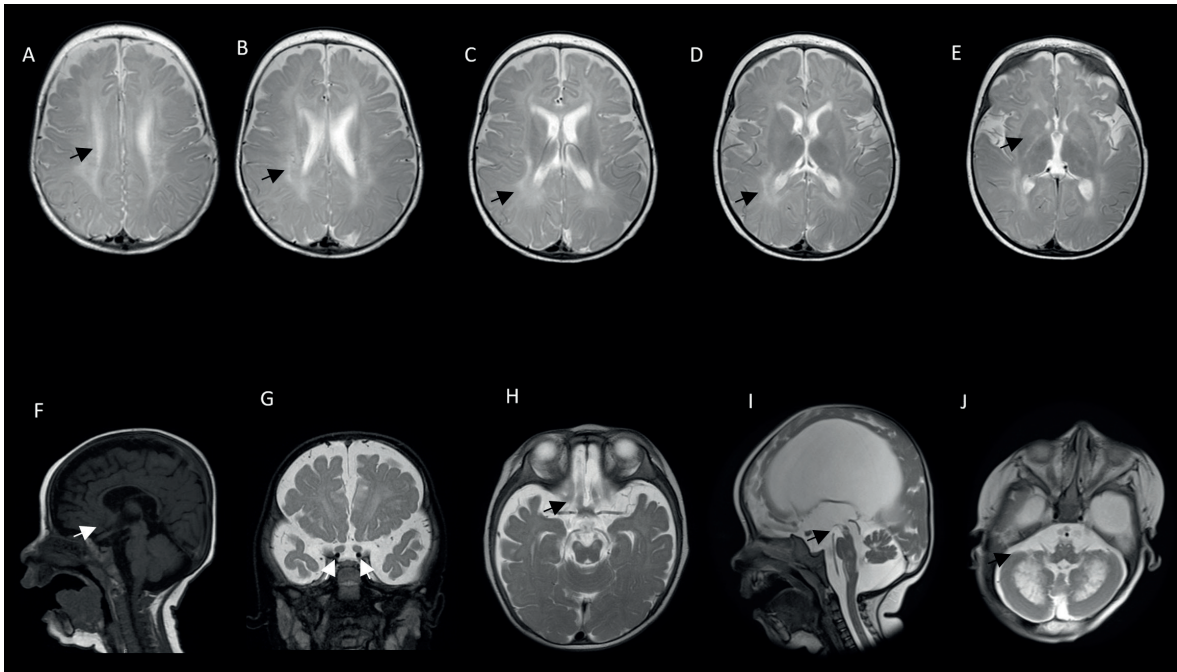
Brain MRI findings in patients with Krabbe disease.
